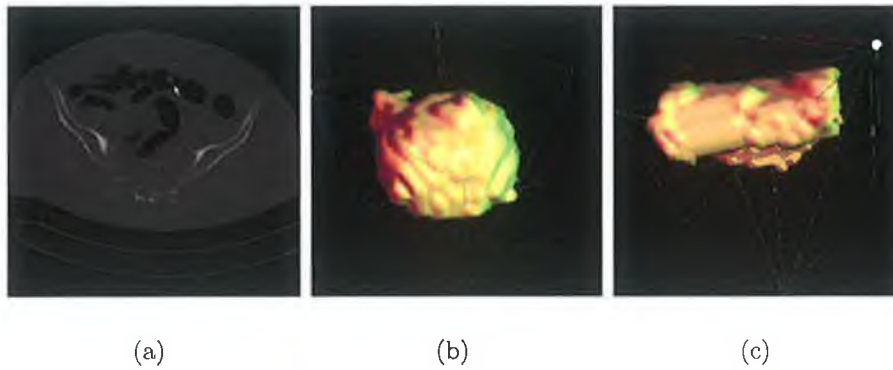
Example of polyp and fold in CT data. (a) A pedunculated polyp shown with arrow sign (b) 3D surface of the pedunculated polyp (c) 3D surface of a fold.
